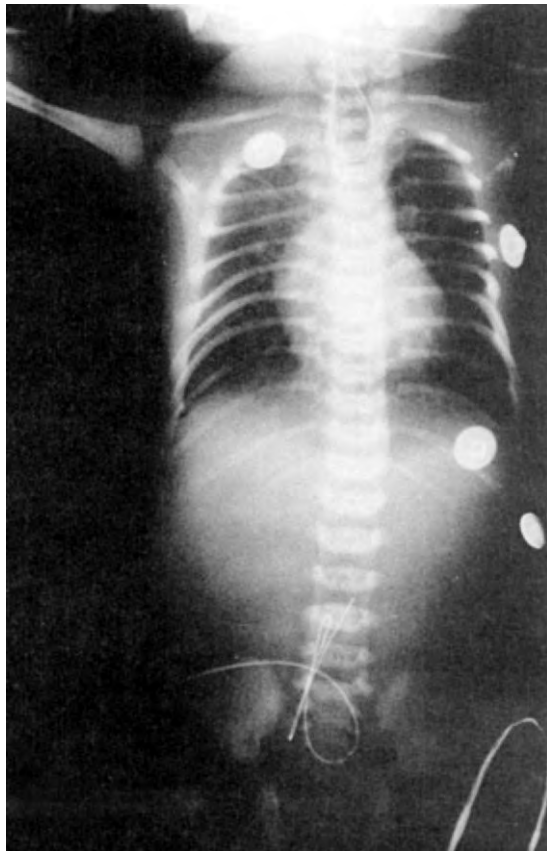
Typical radiograph in an infant with esophageal atresia demonstrating the orogastric tube coiled in the atretic proximal esophagus without a patent tracheoesophageal fistula as shown by the gasless abdomen. (From Ashcraft KW, Murphy JP, Sharp RJ, et al [eds]: *Pediatric Surgery*, 3rd ed. Philadelphia, WB Saunders, 2000, p 353.)
